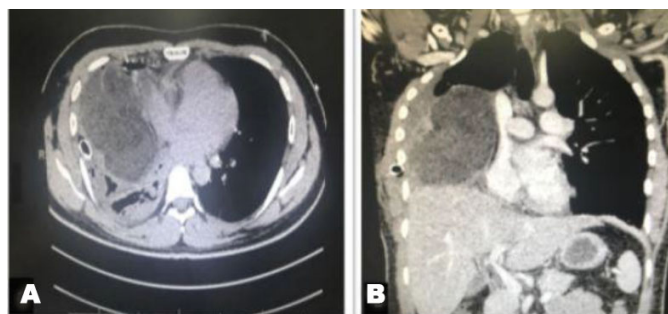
Chest CT scan revealed large, heterogenous, lobulated anterior mediastinal mass (A) compressing the right diaphragm, mediastinal great vessels and right hilar structures (B).
